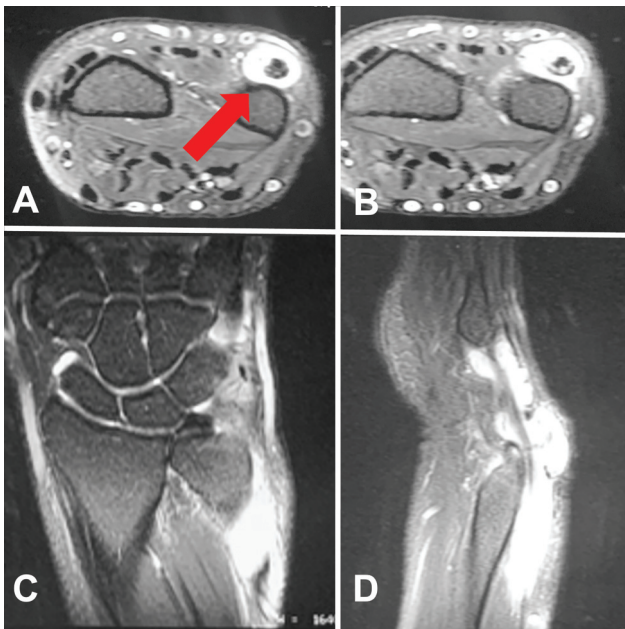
MR images demonstrate tenosynovitis of the ECU (red arrow) with little intra-articular involvement. Transverse (A and B), coronal (C), and sagittal (D) views.
